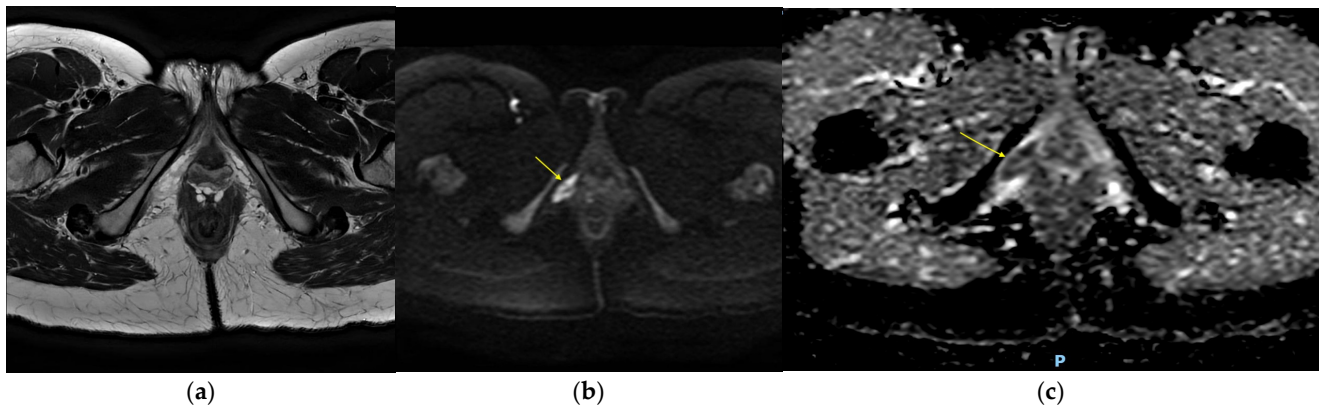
(a) Axial T2-weighted MRI image, no lesion identified (anatomical landmark). (b) Axial diffusion-weighted MRI image shows high signal intensity at the resection site (between the vaginal and the ischiopubic ramus). (c) The apparent diffusion coefficient (ADC) shows low signal intensity and diffusion restriction.
